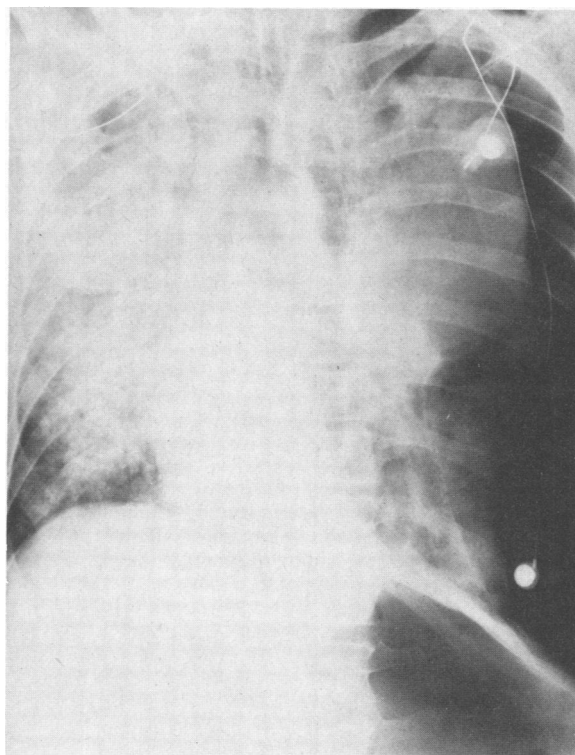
Roentgenogram of the chest on June 2, showing large pneumothorax and pneumoperitoneum.
